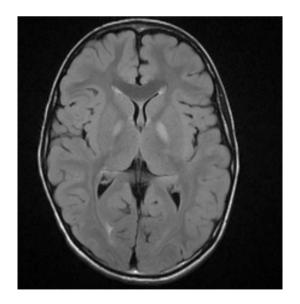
Axial T2 FLAIR sequence showing hyperintensity in globus pallidus, bilaterally
